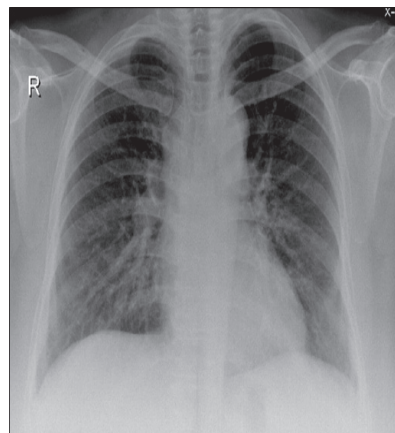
PA Chest Radiograph showing Ground Glass Opacities in the Left Lower Zone
